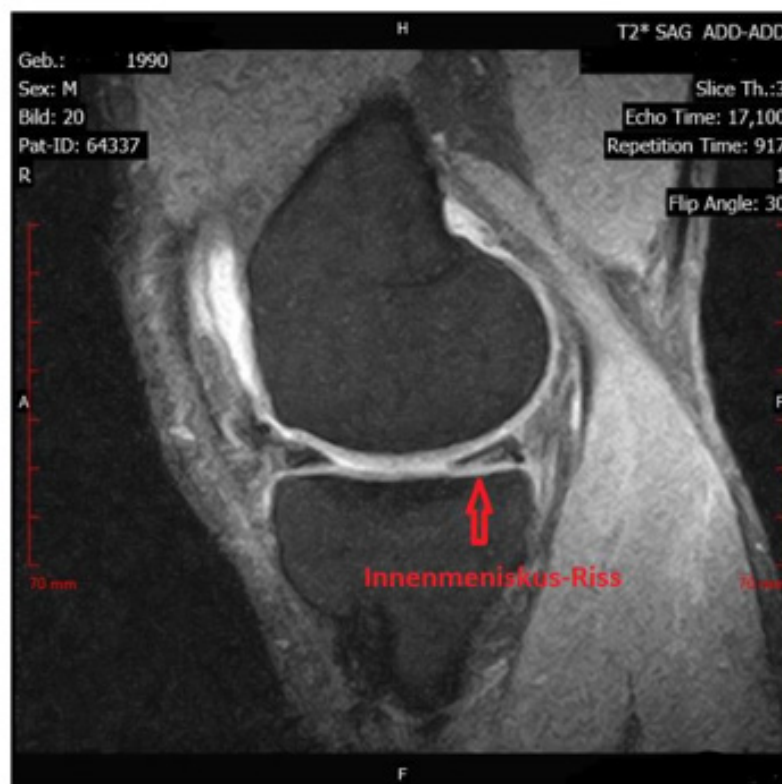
MRI images of a medial meniscus.
